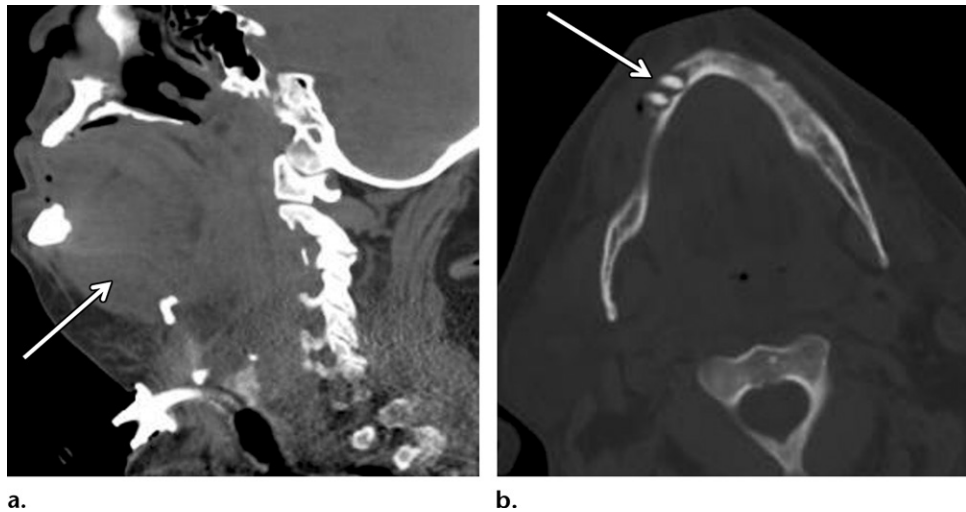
Ludwig angina in a 58-year-old man who presented with a sore throat, fever, chills, muffled voice, difficulty breathing, and drooling. (a) Sagittal CT image shows extensive soft-tissue swelling and stranding involving the floor of the mouth and tongue (arrow). (b) Axial CT image (bone window) shows an anterior mandibular tooth infection (arrow) as the underlying cause. The extensive soft-tissue swelling caused posterior displacement of the tongue and complete obstruction of the pharyngeal airway, resulting in the placement of an emergency tracheostomy tube, which can be seen in a.
